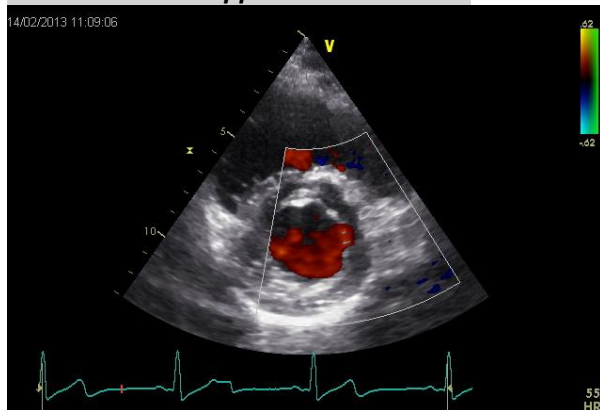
color Doppler at mitral valve
